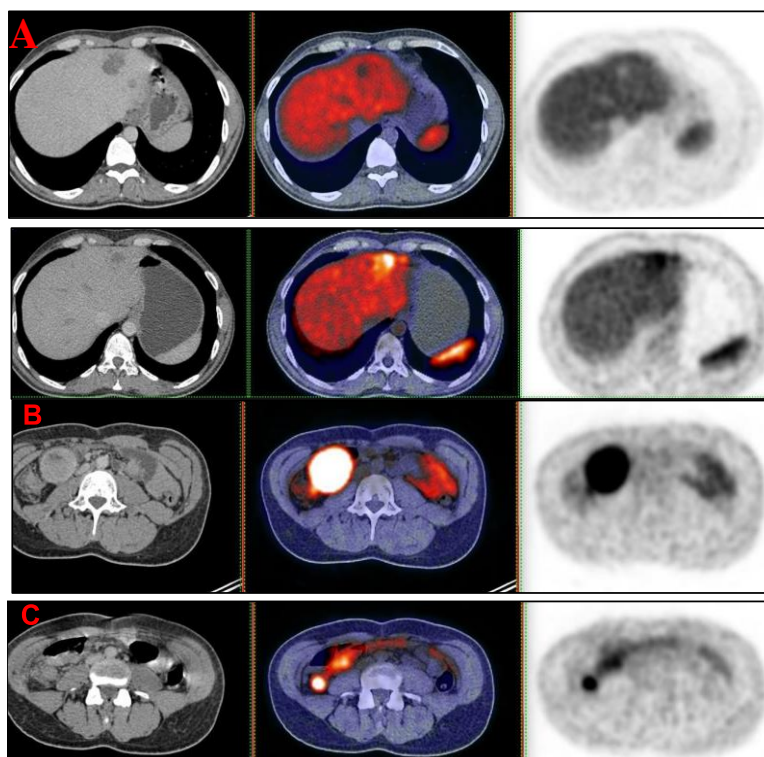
A 57-year-old male patient complained of bleeding per rectum and had imaged-based suspicion of NETs (by abdominal CT). ^{68}Ga -DOTATATE PET/CT precisely localized the 1ry and the metastatic sites A) hepatic avid lesions, B) right lumbar enhancing mass, C) terminal ileum lesion (1ry site).
